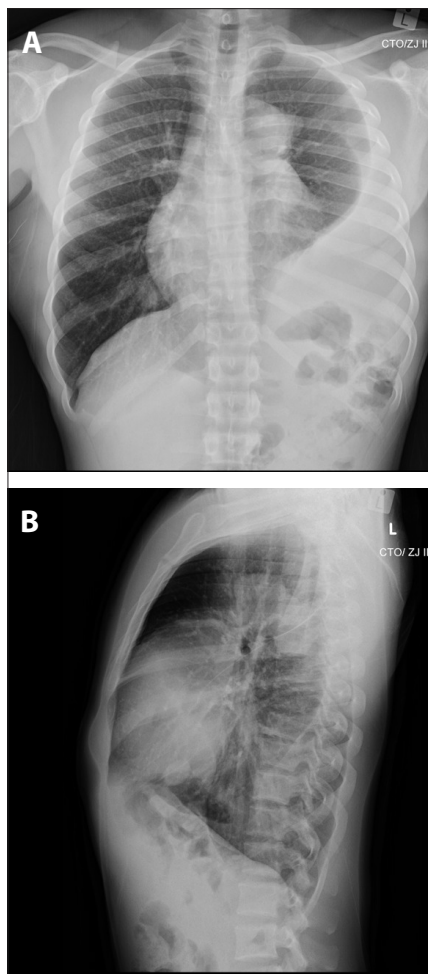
Frontal (A) and lateral (B) chest radiographs showing a large opacity within the left hemithorax with loss of the left costophrenic and cardiophrenic angles associated with a meniscus, and mild deviation of the mediastinum to the right in keeping with a large left pleural effusion. Associated hilar and mediastinal lymphadenopathy is present.
